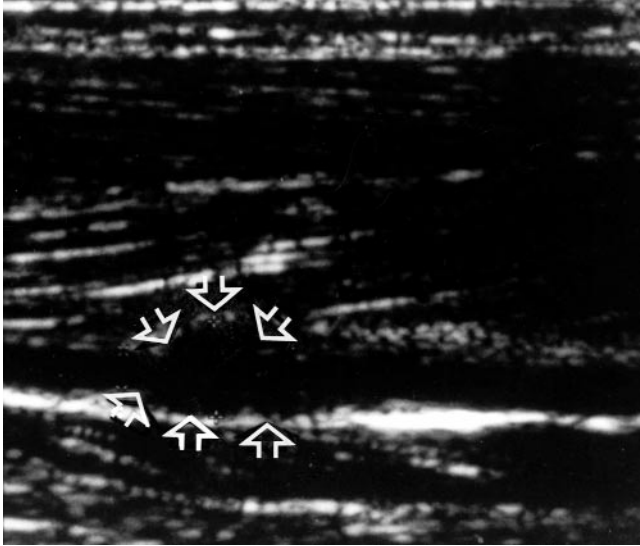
Ultrasound scanning showing a 5.2 mm diameter aneurysm (arrows) on a 2.2 mm tibial artery.
